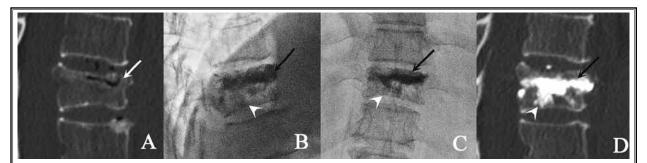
(A) A 65-year-old woman was admitted due to a severe backache for 2 years. She was diagnosed with IVC at the anterior one-third of T11 vertebra (white arrow). (B, C, D) A sagittal computed tomography image shows an IVC near the upper endplate. After RC-PVP, the IVC is filled mainly by a mass of cement (black arrows), spreading into the fine bone trabeculae (white arrowhead).
